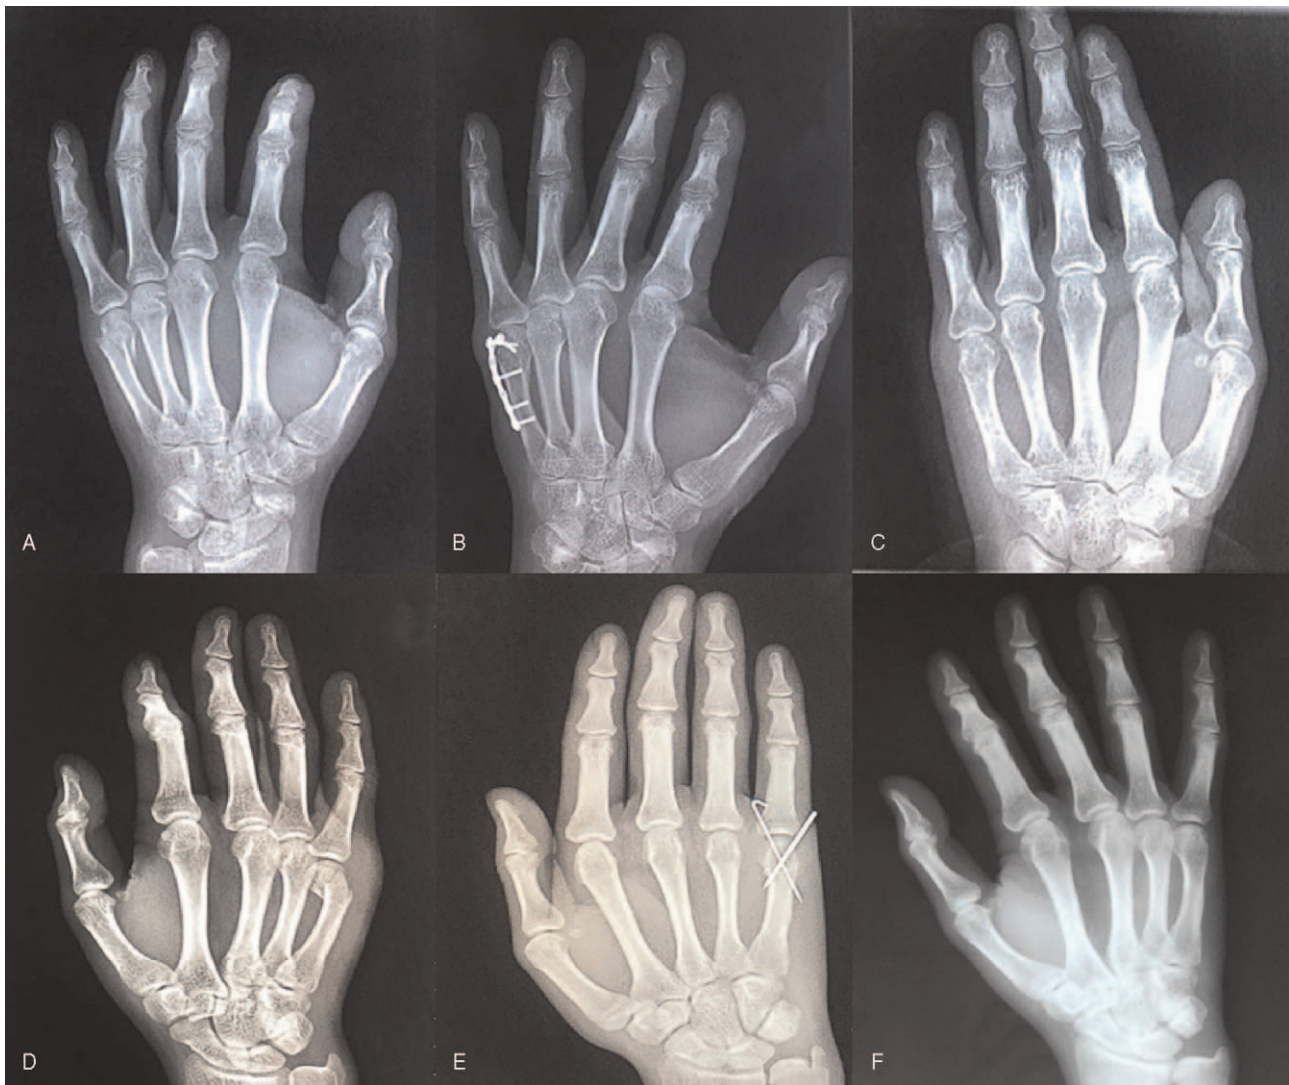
A 18-year-old patient sustained a fracture of the right fifth metacarpal and was treated with internal fixation: (A) Radiographic evaluation on the day of fracture; (B) Radiographic evaluation postoperation; (C) Radiographic evaluation after recovery. A 39-year-old patient sustained a fracture of the left fifth metacarpal and was treated with kirschner wire: (D) Radiographic evaluation on the day of fracture; (E) Radiographic evaluation postoperation; (F) Radiographic evaluation after recovery.
